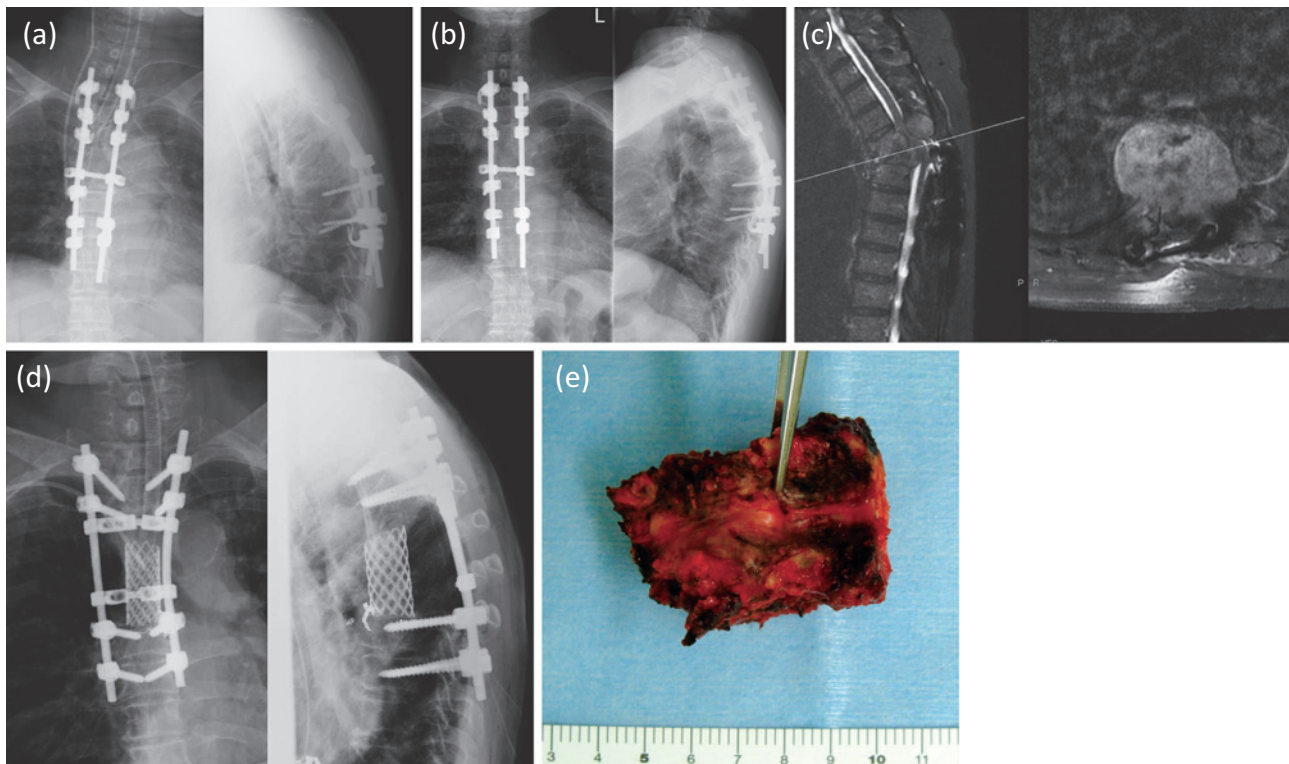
Plain radiographs (a) soon after the first surgery, (b) right before the second surgery. (c) MRI images of the recurrent tumor after the first surgery. (d) Plain radiographs after the second surgery. (e) Excised vertebra.
